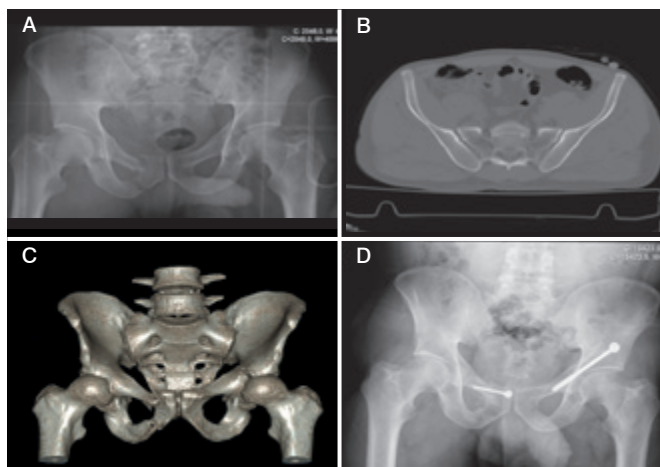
Patient with both transverse acetabular fracture and contralateral sacroiliac joint separation. (A) Preoperative X-ray (B) Preoperative CT scan (C) Preoperative CT scan (3D) (D) Postoperative X-ray.
